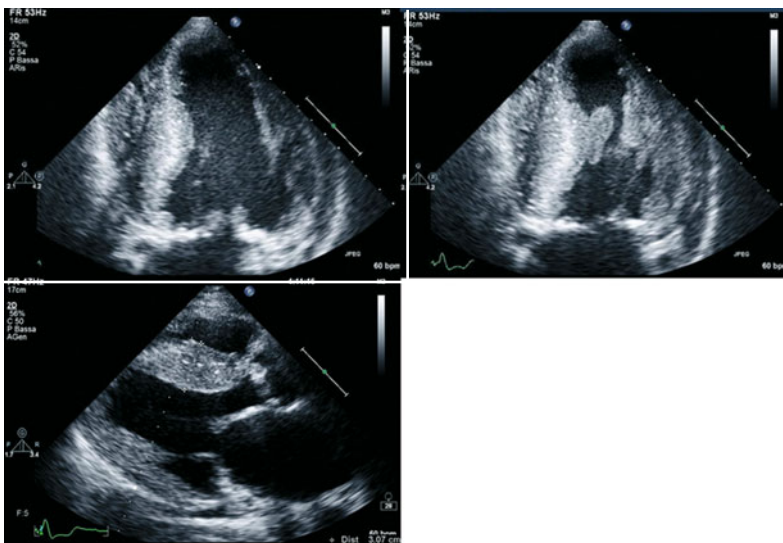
Two-dimensional echocardiogram from a 52-year-old man with Fabry disease and cardiac involvement. *Upper panels* apical four-chamber views, end-diastolic and end-systolic frames. *Lower panel* parasternal long-axis view, end-diastolic frame. The left ventricle is severely hypertrophic (interventricular septum thickness 29 mm) and moderately dilated (end-diastolic volume 175 ml); an apical hypokinesis is present. A “granular sparkling” appearance of ventricular myocardium is evident. The global systolic function is at the lower limits of normality (ejection fraction: 51%). There is moderate thickening of valve leaflets without significant stenosis
